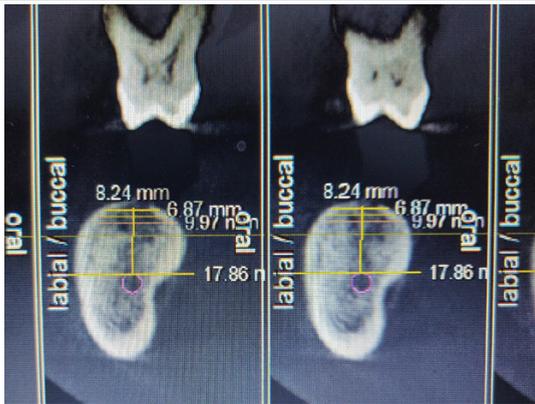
Pre-operative CBCT depicting available alveolar height in left mandibular 1st molar region.
